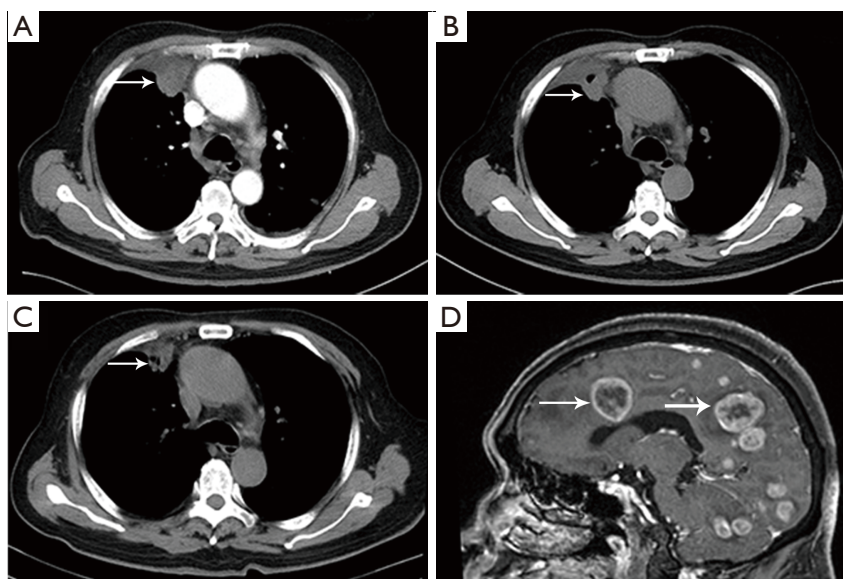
Computed tomography (CT) scan of the thorax before treatment. Lung adenocarcinoma in the upper lobe of the right lung (white arrow) revealed by radiologic.
